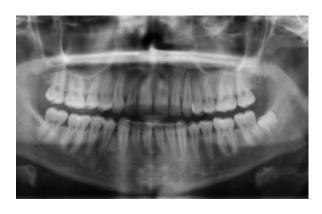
Final situation: intra-oral pictures and X-Rays after the treatment.
